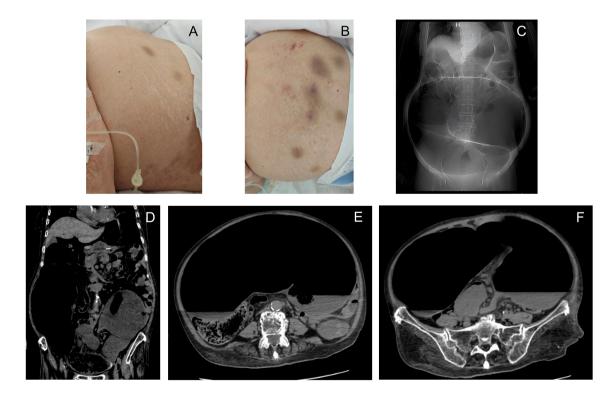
Belly bulge of the patient (A,B). Plain abdominal radiograph shows coffee bean sign (C). Coronal (D) and axial (E,F) CT imaging shows airfluid level and extreme dilatation of the bowel.
